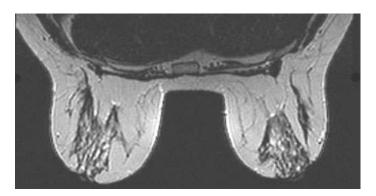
Breast MRI: T2-weighted image .Fat is bright, fibro glandular tissue dark, quoted from (Ryan et al., 2004).
